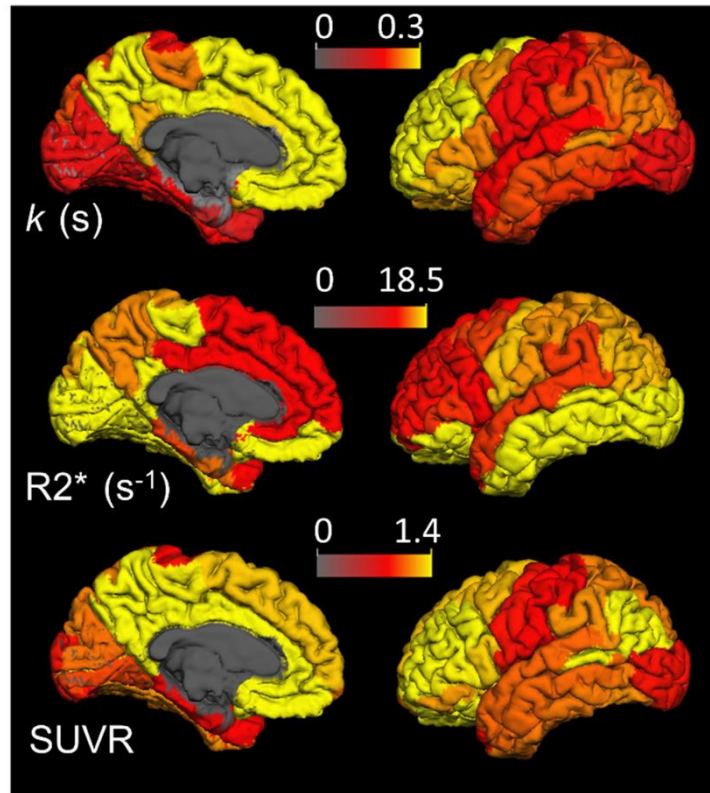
Upper row represents the surface maps of the slopes (units of sec) of linear regression (coefficient k_{ROI} in Equation (4.2)) between regional PET-measured $A\beta$ SUVR and parahippocampal $R2^*$ across 19 participants. All regional slopes are positive. The coefficients of the linear regressions are listed in Table 4.2. The second and the last rows represent the averaged cortical mean values of $R2^*$ and $A\beta$ SUVR across the same 19 participants. White matter, deep gray matter and ventricles were excluded. The image segmentation is based on the FreeSurfer software (76).
